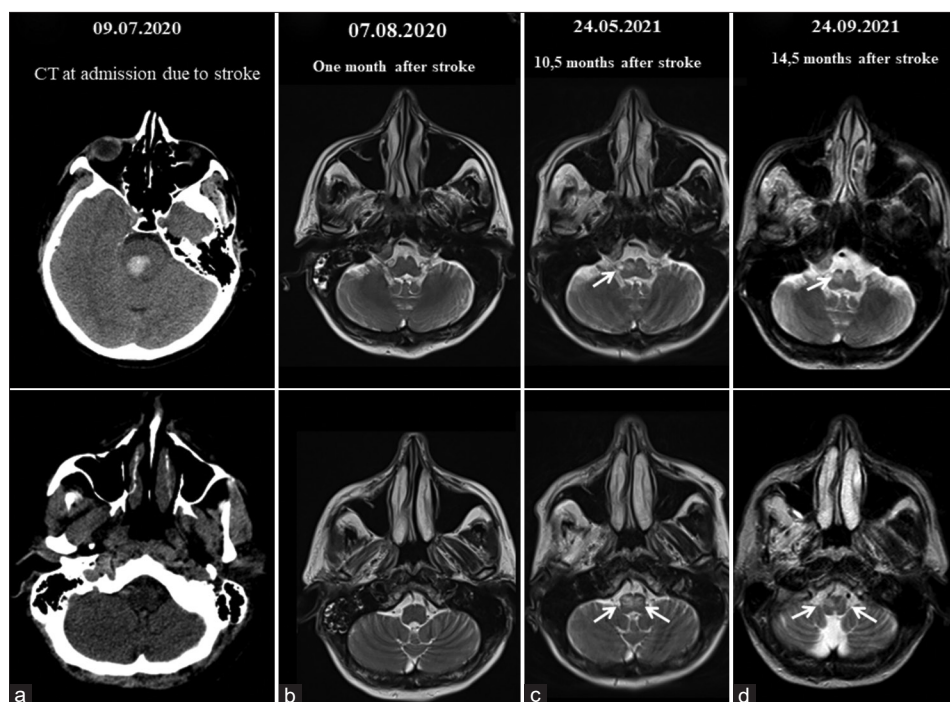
The figure showing the temporal course of the neuroimaging findings of the bilateral hypertrophy of the inferior olivary nucleus, prominent on the right side. (a) The cranial tomography showing the right pontine hemorrhage. (b) Cranial MRI, performed one month after the event, showing a normal appearance of the inferior olivary nucleus. (c) Cranial MRI, performed 10 months after the event, showing the development of the hypertrophic inferior olivary nucleus. (d) MRI, performed 14 months after, shows the persistence of the appearance
